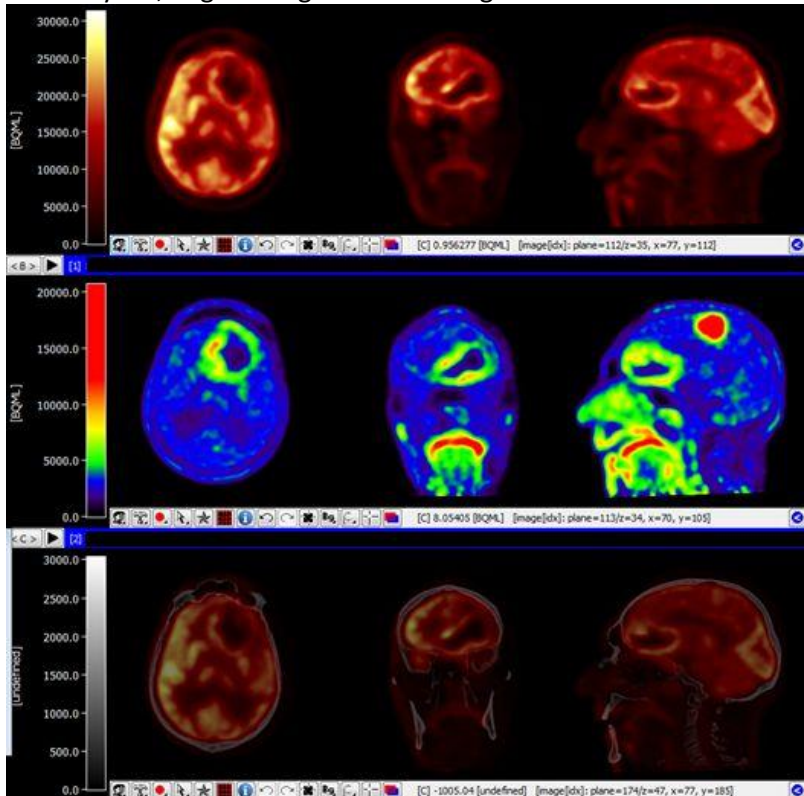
Brain tumors of grade 3 and grade4 imaged in one patient with FDG (upper panel, combined with CT – lower panel), Methionine (middle panel)
